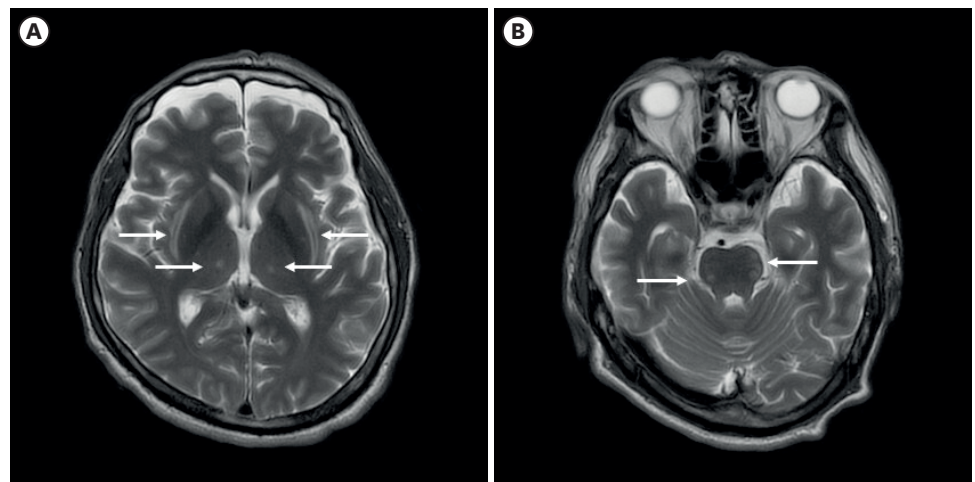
A follow-up brain magnetic resonance imaging (hospital day 14). Symmetrical T2 hyperintensities in the (A) external capsules, thalami, (B) hippocampi, and peripheral pons. These findings suggest metabolic encephalopathy, such as osmotic demyelination syndrome (arrows).
